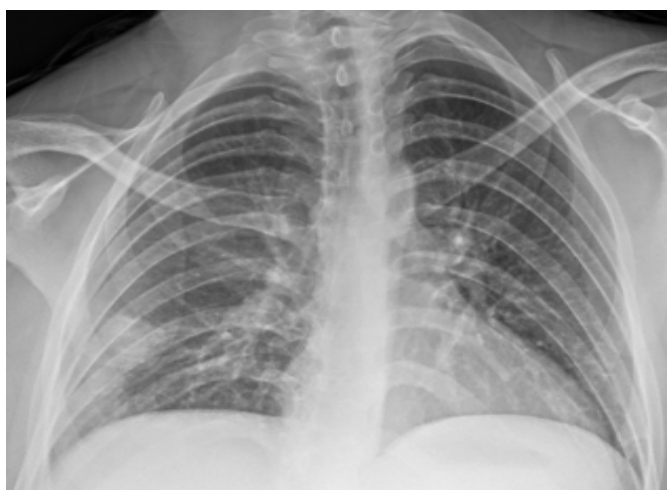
Antero-posterior chest radiograph withdrawn when complaints started
